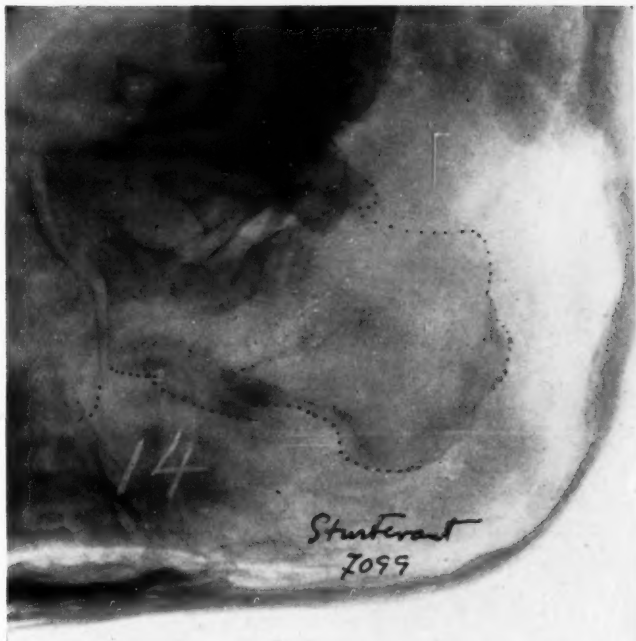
After reduction. A case with marked deformity at the start (X-rays taken lost). Shows, after reduction, both general bone outline and joint relations not far from normal. This man recovered nearly all his lateral motion and obtained an excellent result.
